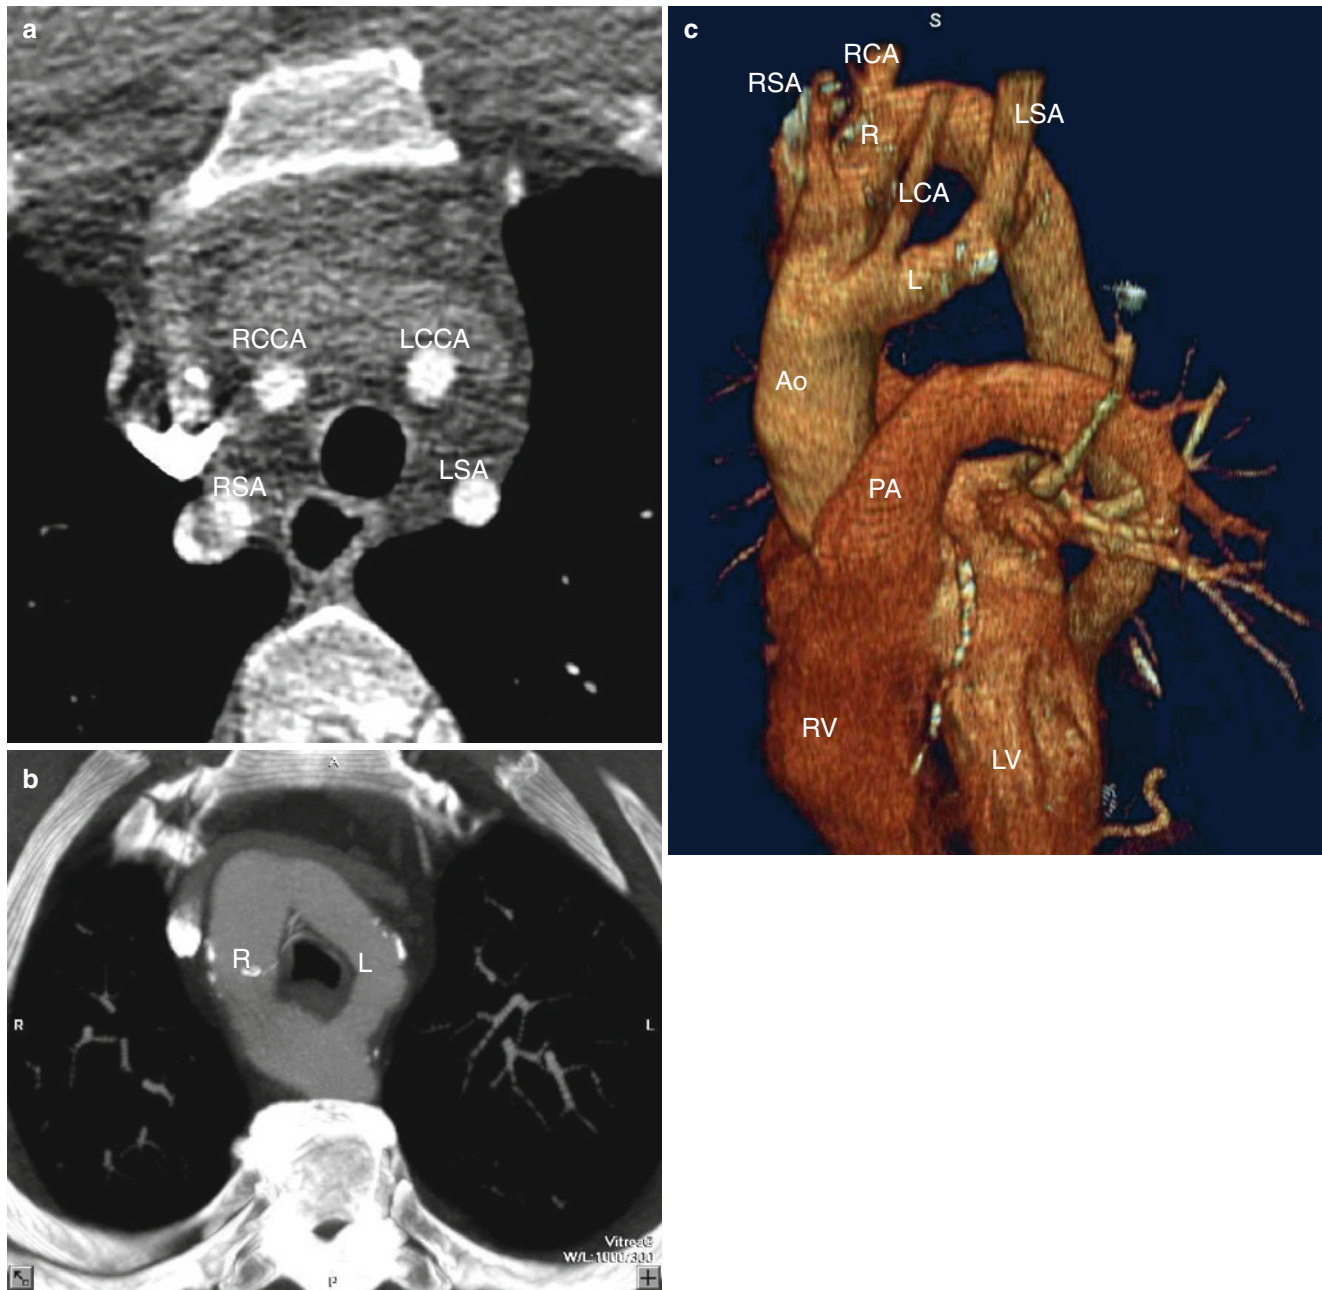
Double aortic arch. Panel (a) is an axial image showing four separate branch vessels. *RSA* right subclavian artery, *LSA* left subclavian artery, *RCCA* right common carotid artery, *LCCA* left common carotid artery. This anatomy is abnormal since in the normal anatomy there is right brachiocephalic artery and separate origins for the left carotid and subclavian arteries. Panel (b) is another axial CT section showing a complete ring around the esophagus and trachea formed by a
